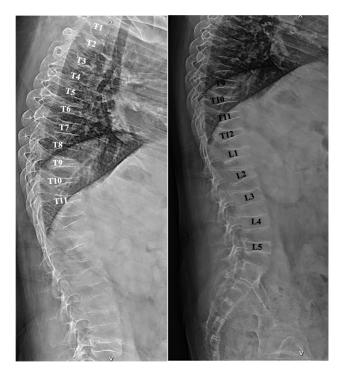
Lateral thoracolumbar spine radiographs of patient 4 who had the most severe vertebral fractures. L, lumbar vertebral level; T, thoracic vertebral level.
